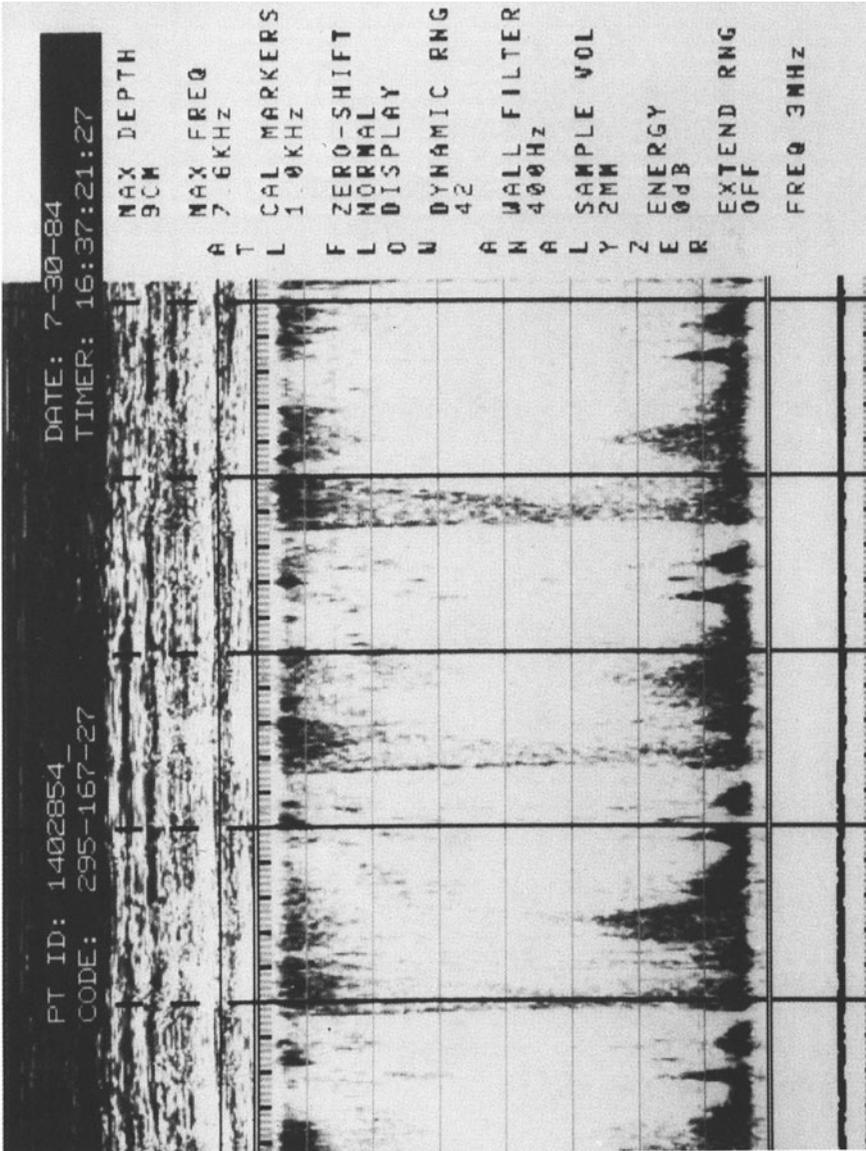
Doppler sample volume within the right atrium from a patient with heart block and tricuspid valve insufficiency. The regurgitant waves on the spectral tracing are occurring at 55 beats/min.
